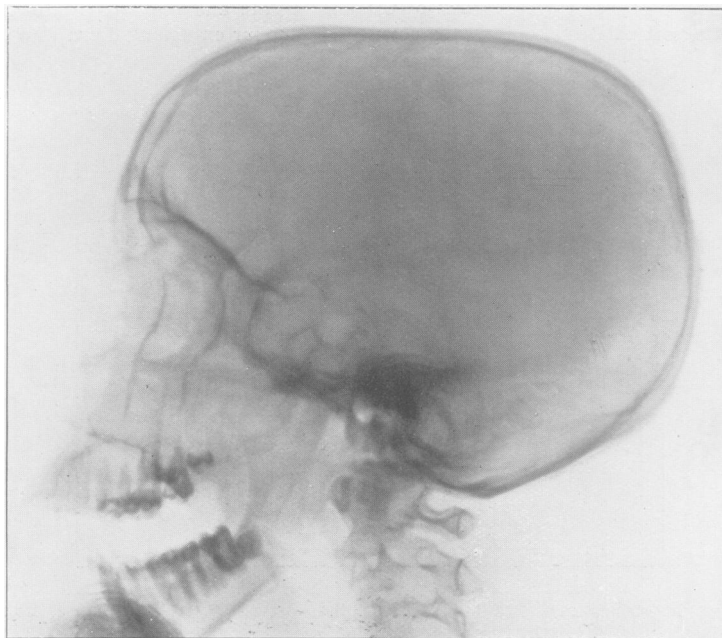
Radiograph of skull showing extensive destruction of the sphenoid and basi-sphenoid.
